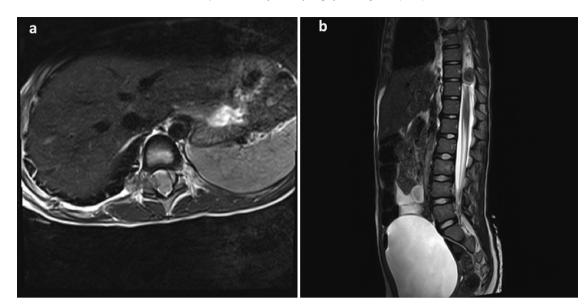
Axial (a) and sagittal (b). MRI depicting severe compression of the spinal cord at the T10–11 level. Note the severe compression of the spinal cord that pushed to the left side of the central canal (b).
